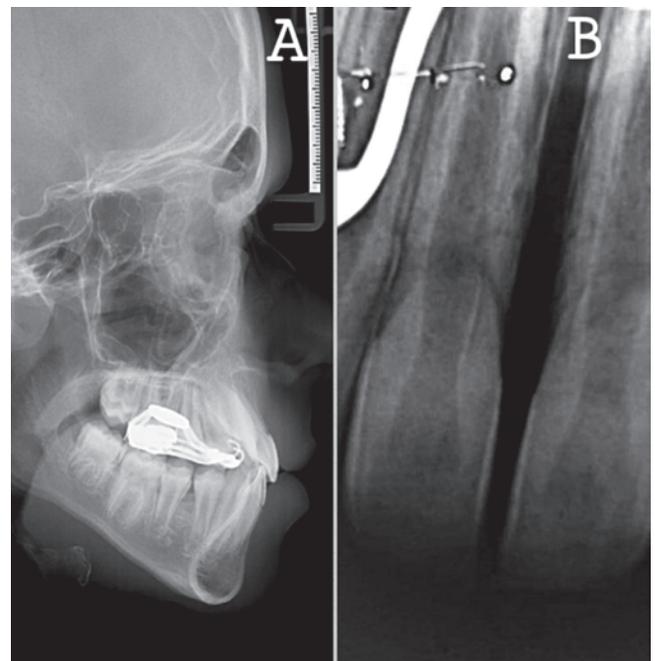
Post-treatment files: A) Lateral cephalogram; B) Periapical radiograph after the palatal suture disjunction.
